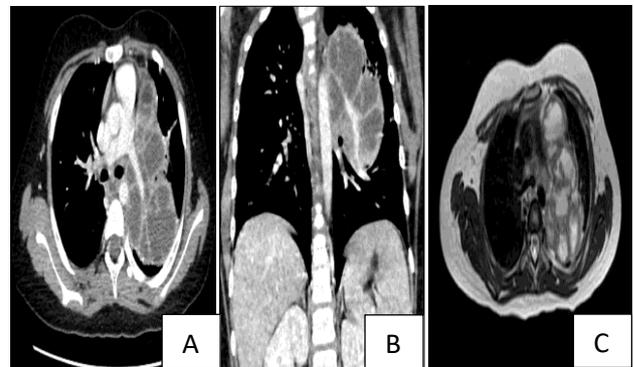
(A-C): CE MRI - a large well defined multiloculated cystic lesion measuring approximately 9.7×6.5×7.2 cm (AP×TR×CC) Multiple mediastinal lymph nodes noted, largest measuring 0.85 cm in short axis diameter in left upper paratracheal location, some of them showing heterogenous enhancement.
